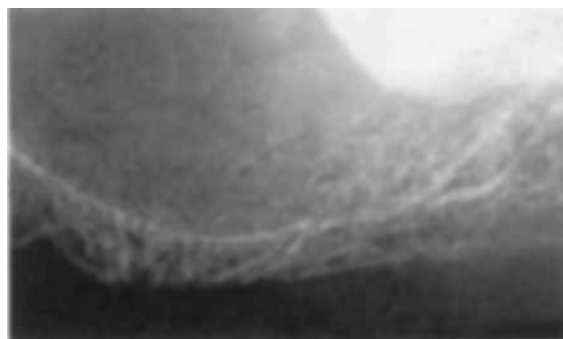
■ Radiograph showing minimal bone depth under sinus.
